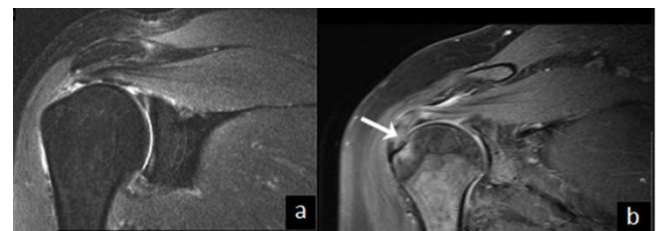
MRI showing full thickness (a) and partial thickness (b) rotator cuff tear
